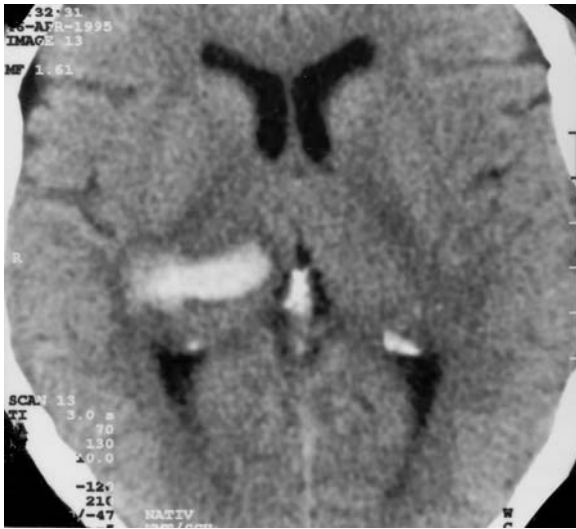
CT of a 41-year-old woman with acute incomplete hemianopia to the left. Diagnosis: spontaneous intracranial hemorrhage of the right thalamus, extending to the proximal part of the right optic radiation. (From MÜLLER-FORELL and LIEB 1995)
